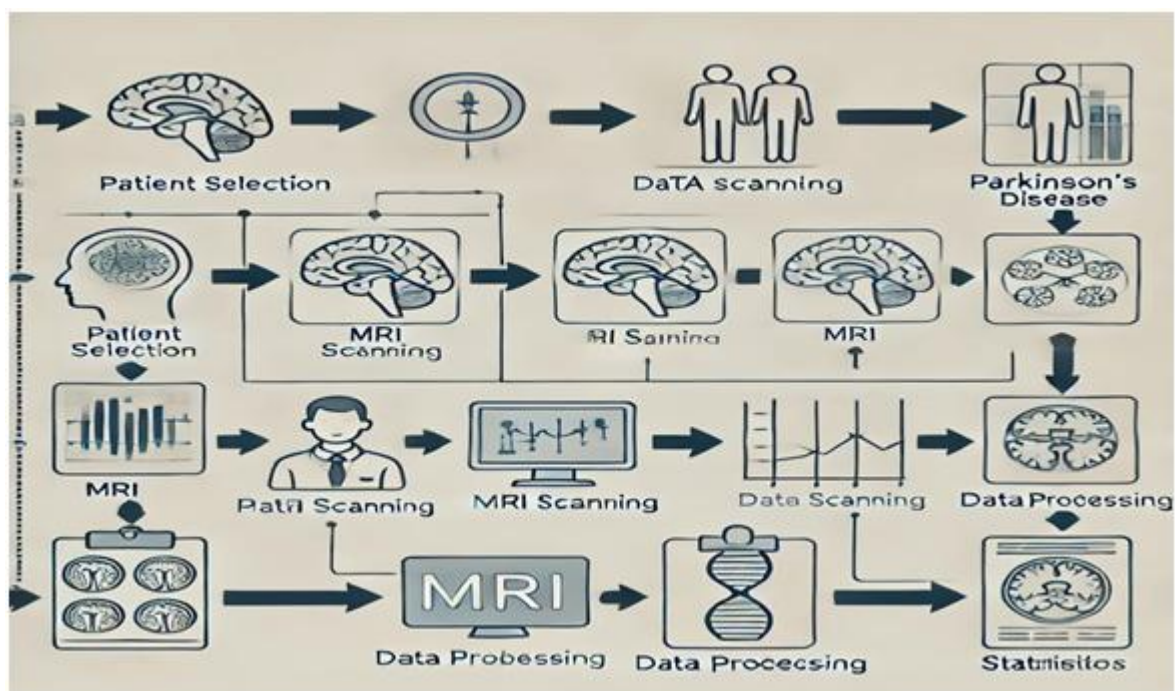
The sequence of stages for participant selection, MRI scanning, data processing, and statistical analysis
